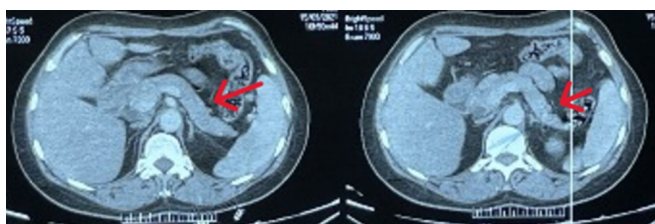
CT scan image showing the normal appearance of the pancreas (red arrow).
